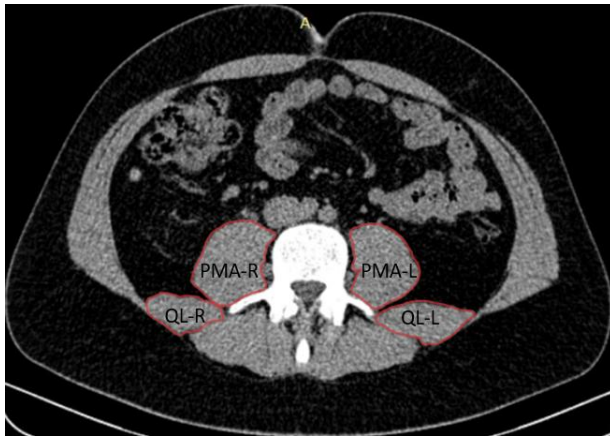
Measurement of muscle size. Axial CT image at the L4 level. PMA-R= right psoas major muscle, PMA-L= left psoas major muscle, QL-R= right quadratus lumborum muscle, QL-L= left quadratus lumborum muscle.
